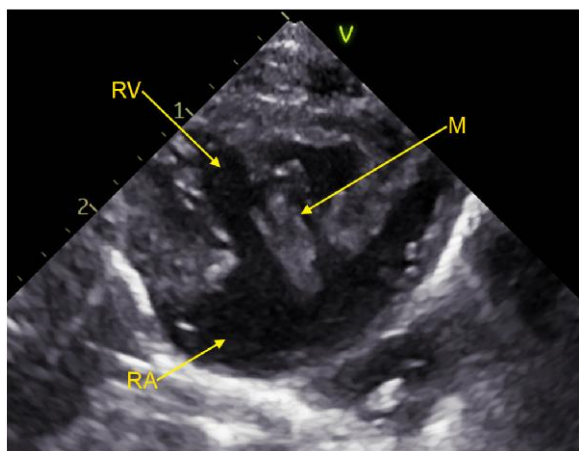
Parasternal long-axis view showing mass (M) in the right atrium on the day of diagnosis. RA, right atrium; RV, right ventricle.
